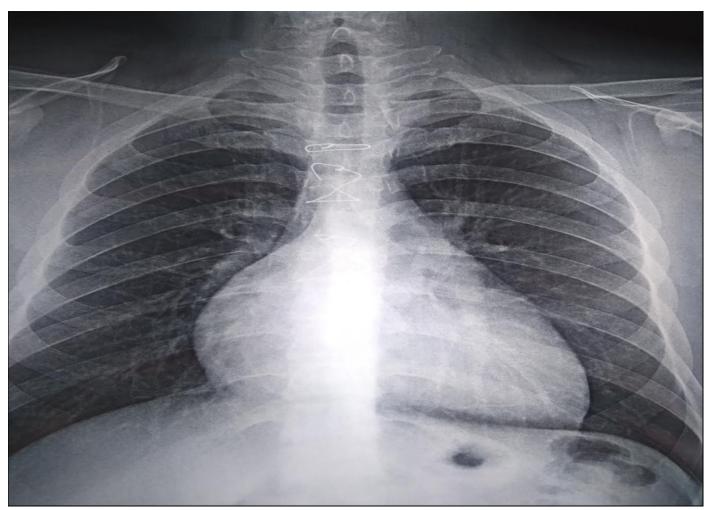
Chest x-ray showed right chamber dilation
